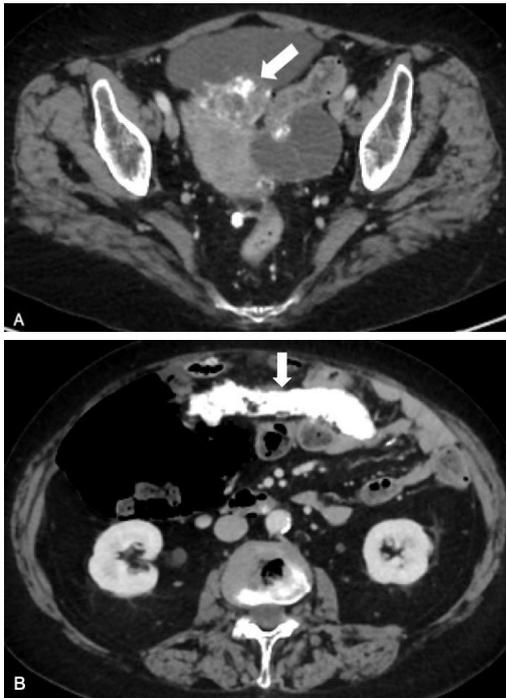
Axial contrast enhanced CT images in portal venous phase from helical CT scan in June 2019. Pelvic CT scan (A) showed a right ovarian mass (arrow) consisting in both solid and cystic components, whereas in upper slices (B) a partially calcified peritoneal implant (arrow) along the greater omentum was present, sign of large peritoneal carcinomatosis.
